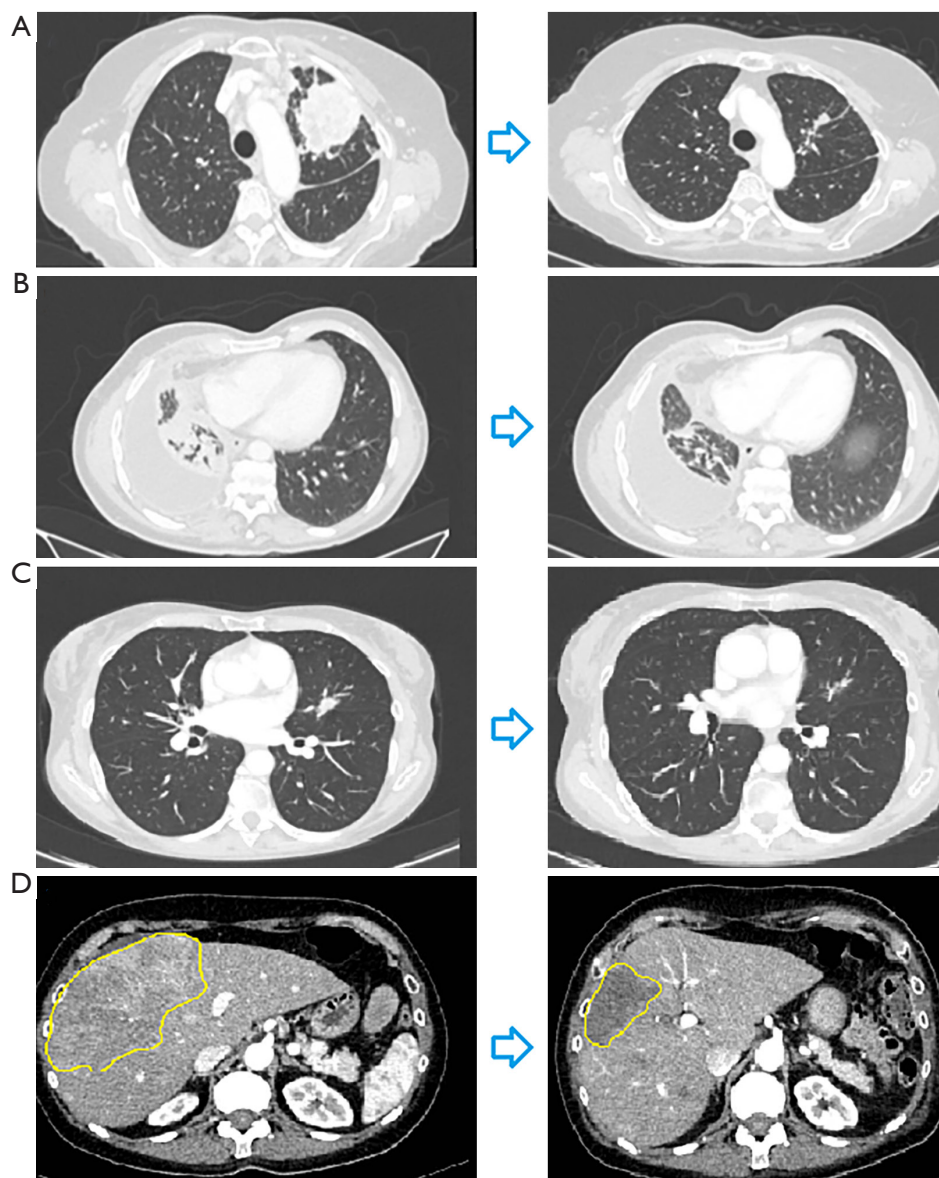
First CT reevaluation during treatment with Pralsetinib. (A-C) CT scan shows side reduction of lung cancer of the first three cases. (D) CT scan shows necrosis and significant reduction of liver metastases in the last cases of this series. CT, computed tomography.
